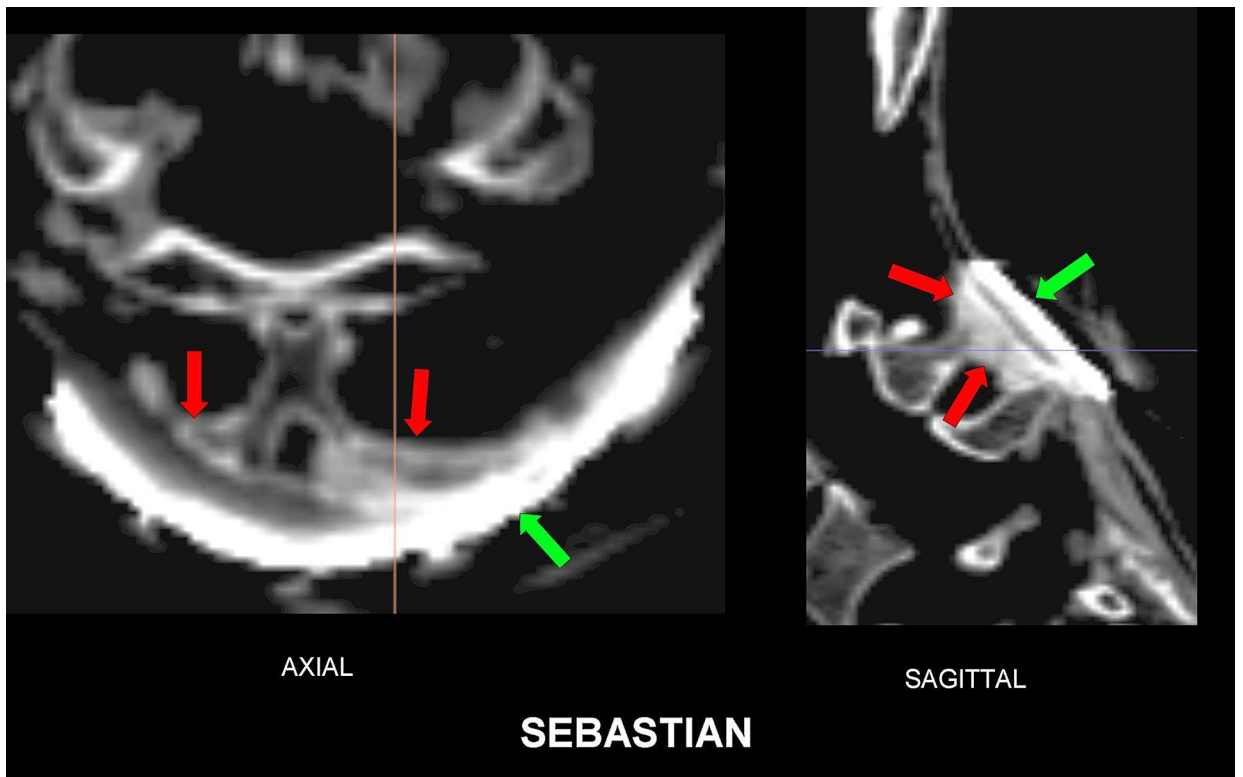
2D axial (*left*) and sagittal (*right*) CT scans showing new bone formation (*red arrows*) from spinous processes of C2 and C3 incorporating into the collar like metallic implant (*green arrow*) in posterior neck indicating a functional implant.
